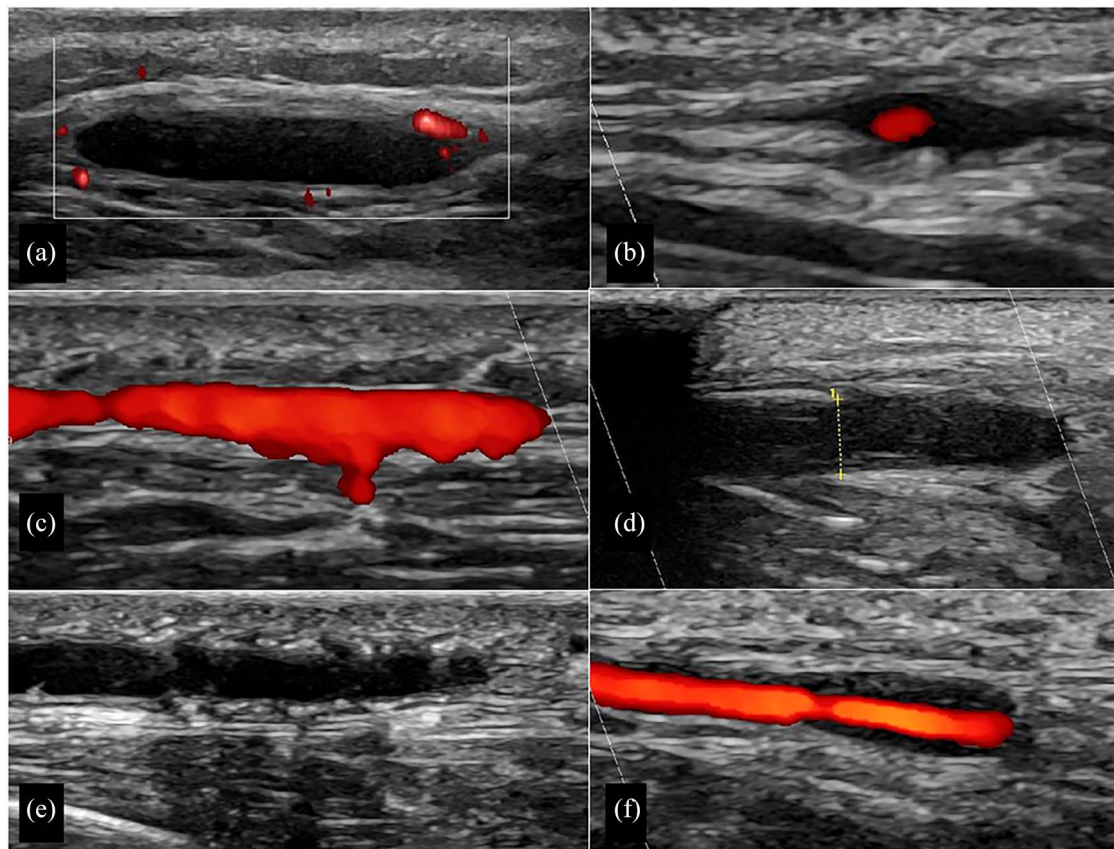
Pitfalls: (a) The colour box is not angled resulting in poor colour Doppler signals. (b) Pseudo-halo because colour gain is too low. (c) Colour gain is too high, while colour signals extend over the artery wall. (d) Hair impairs sound waves on the left side of the image, but vasculitic artery is not compressible on its right side. The callipers indicate a thickness of 2.2 mm for the compressed artery, meaning that each IMT is 1.1 mm. (e) Arteriosclerosis of a temporal artery, displayed as hyperechoic (white) irregular spots in the IMT of both sides. (f) Focal vasculitis on right side with normal temporal artery segment on left side.
